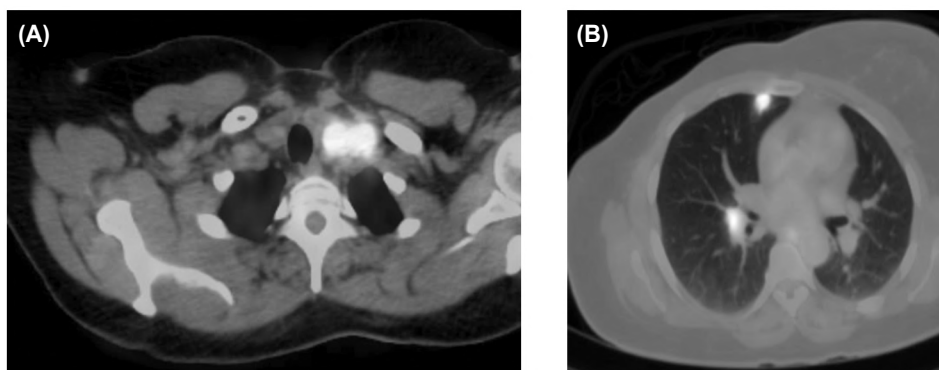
(A, B) PET-CT revealed glucose avid mediastinal LN.s and right lung nodule.
